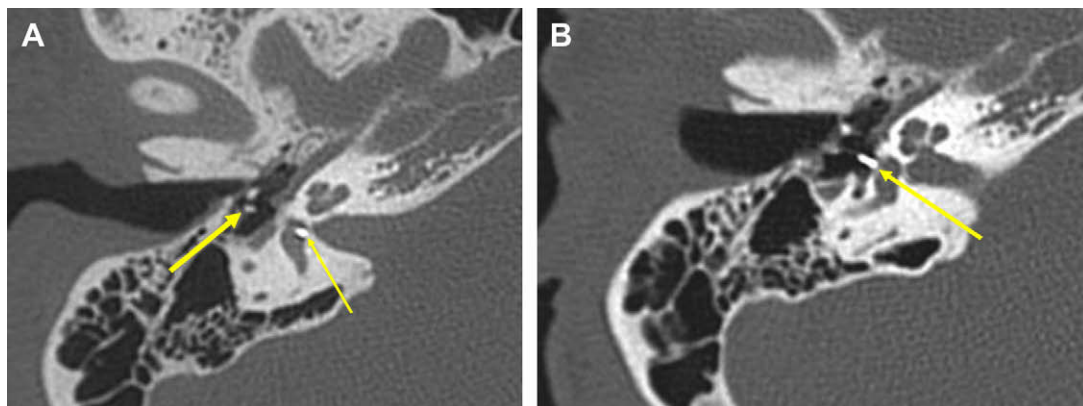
(A) Axial CT image obtained following stapedectomy for otosclerosis. There was postoperative hearing loss and dizziness. Note loss of continuity between the long process of the incus (*thick arrow*) and the prosthesis, which has fallen deep into the vestibule (*thin arrow*). (B) Image from the same patient following revision shows the prostheses now in good position extending from the long process of the incus to the stapes footplate (*arrow*).
